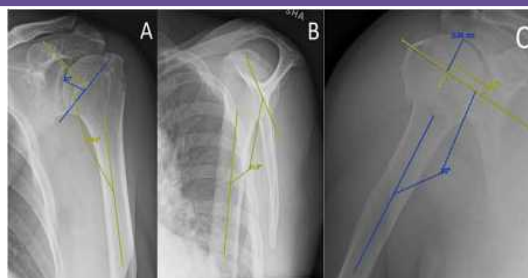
Radiographic parameters measured. A. CCD angle; B. Y-scapular angle; C. HHH
